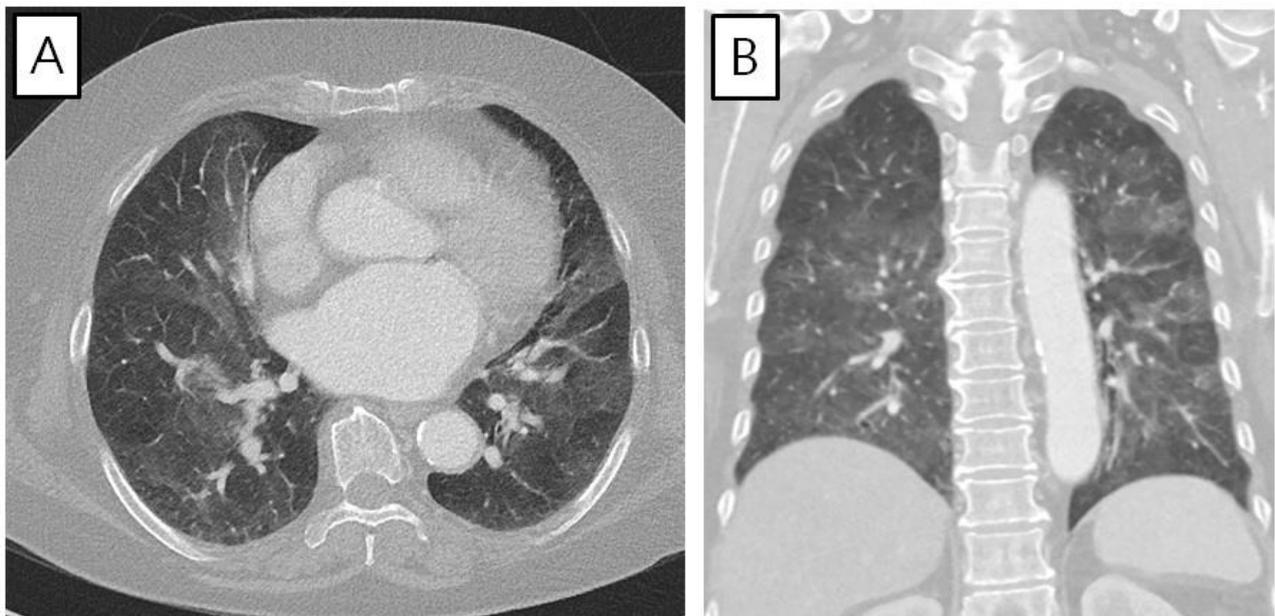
Computed tomography of the chest showing multiple ill-defined ground-glass opacities in both lungs. (A: axial plane, B: coronal plane)
